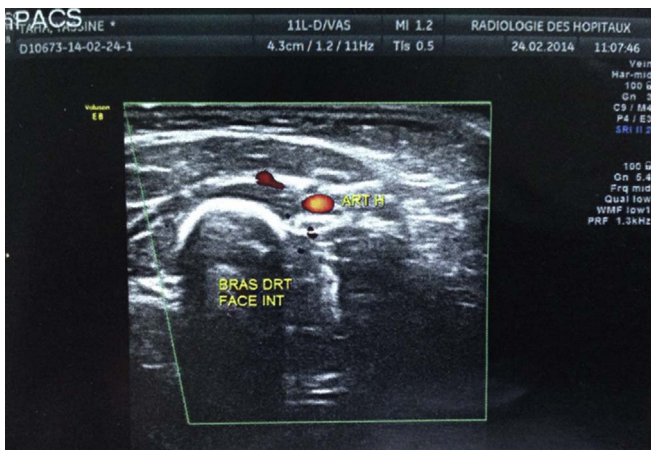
Image of the Doppler showing the humeral pedicle without abnormalities.
